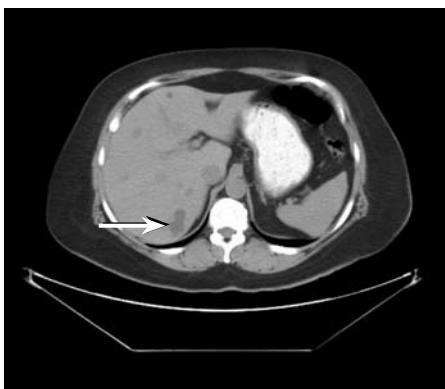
CT of the abdomen without contrast performed on October 15, 2009, demonstrates a lobulated, low-density right posterior hepatic lobe lesion (arrow) that corresponds to the location of abnormal increased I-131 accumulation on scintigraphy. This lesion measures fluid density. A few other millimetric low-density lesions are noted within the liver on this transaxial image, too small to characterize.
